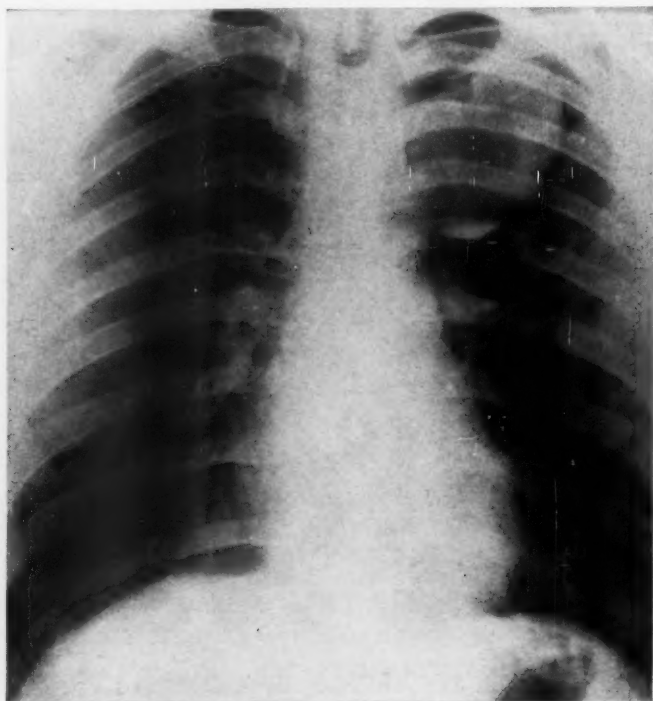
Case 6: Roentgenogram taken on admission demonstrates the sharply defined lesion in the left upper lung field. The area of increased density at the base of the lesion should be noted.
